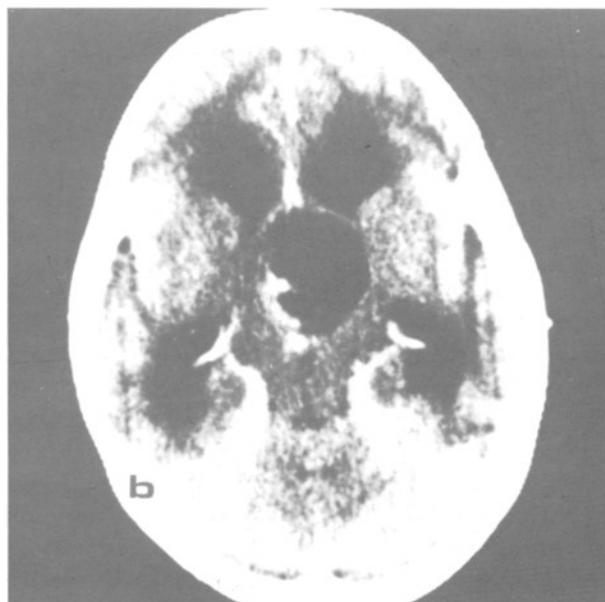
CT scans showing supra sellar cystic tumor, containing calcification (a) and extending into the third ventricle (b).
